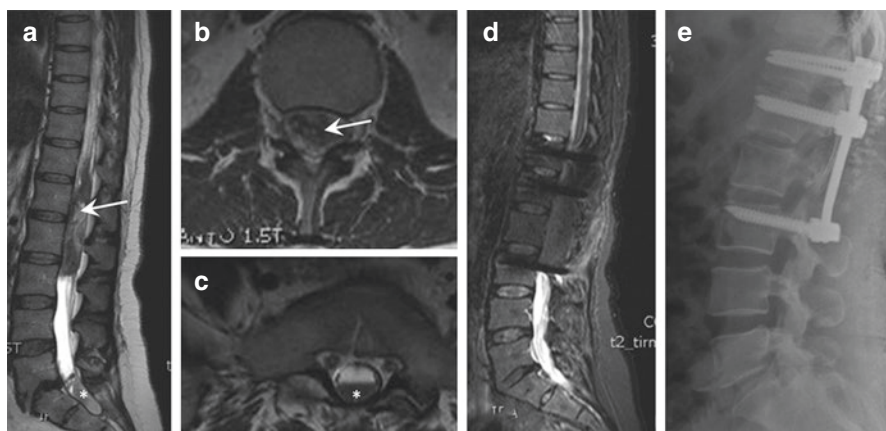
Imaging of a 43-year-old female patient who presented with acute onset of paraparesis and urinary retention (patient operated on by IO). (a) Sagittal T2-weighted MRI of the lumbar spine revealing intratumoral hemorrhage at L1–L3 (arrow) with subdural hematoma at S1 (*) (Type IVA). (b) Axial T2-weighted MRI of the lumbar spine shows the tumor mass (arrow). (c) Axial T2-weighted MRI of the lumbar spine showing subdural hematoma at S1 (*). Complete tumor resection and evacuation of the hematoma were performed. Due to laminectomy over 3 levels, additional spinal stabilization was performed. (d) Postoperative sagittal T2-weighted MRI of the lumbar spine following tumor resection and hematoma evacuation showing complete resection without residual hematoma. (e) Postoperative sagittal X-ray of the lumbar spine demonstrating T12–L3 stabilization of the thoracolumbar transitional area
